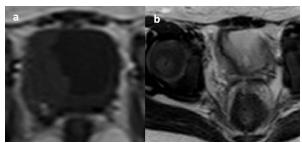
Right bladder wall thickening on T1 and T2 MRI sequences.
